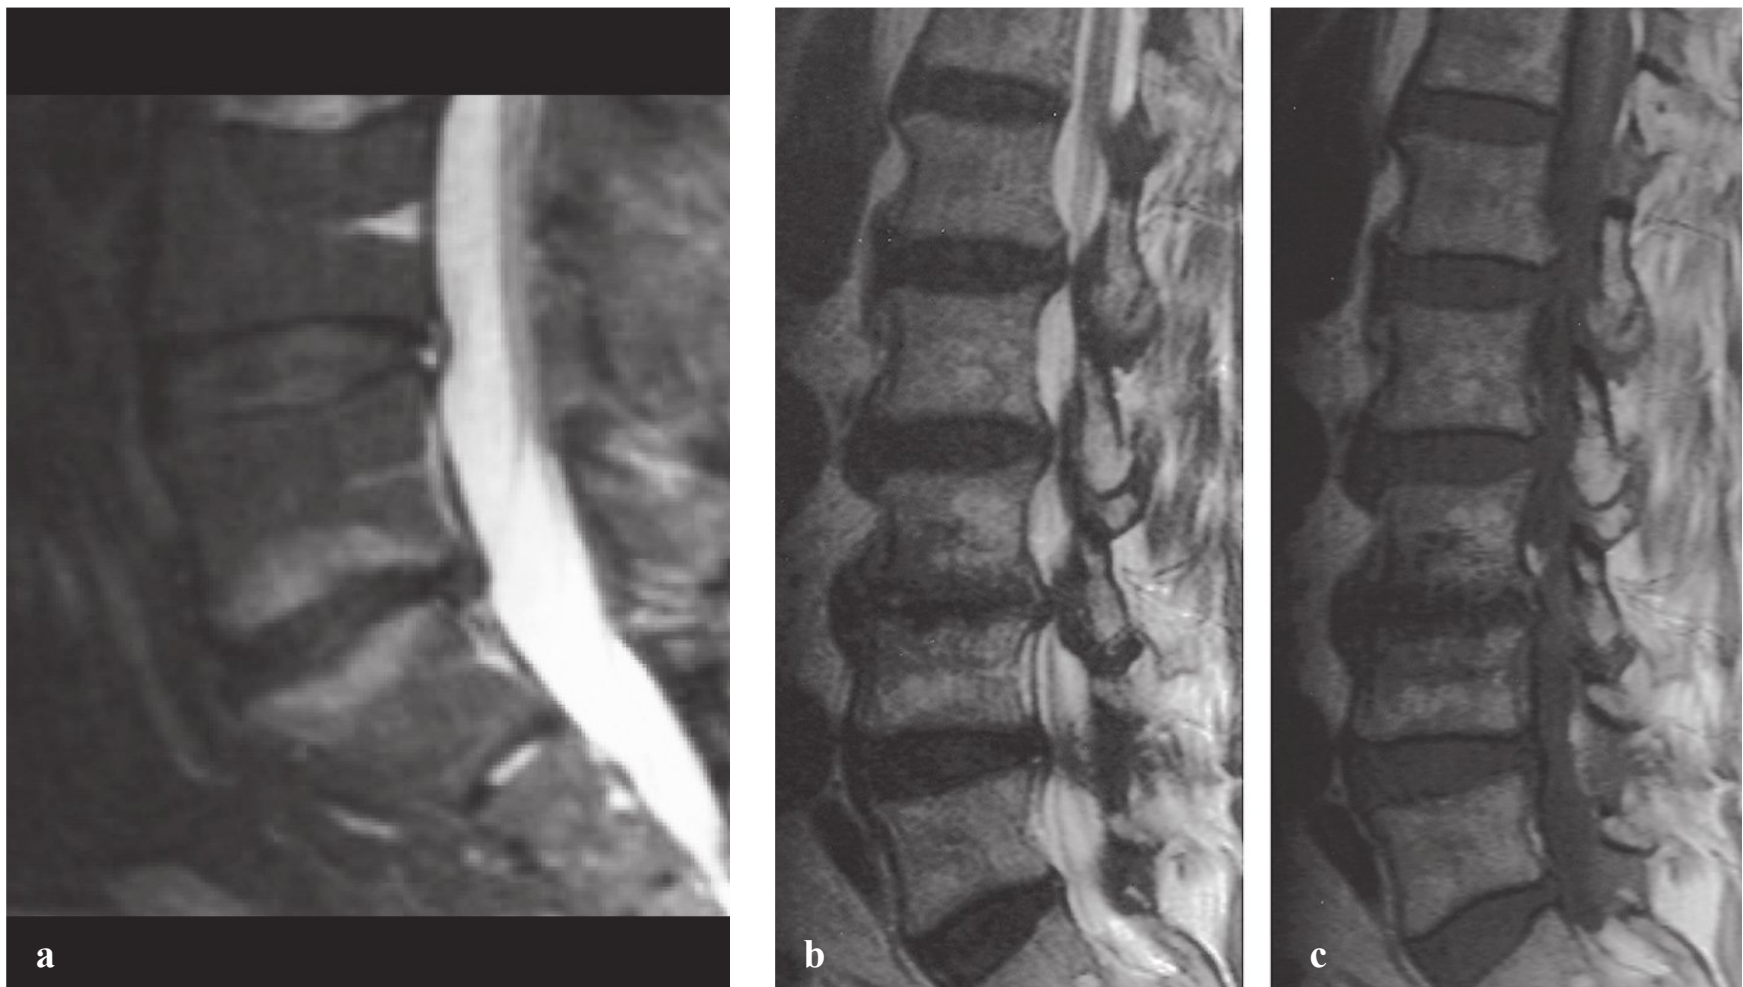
(a–c) Sagittal magnetic resonance imaging demonstrating type 1 Modic changes. (Reproduced from Imhof H, et al. Spinal Imaging. Direct Diagnosis in Radiology Series. Stuttgart, Germany: Georg Thieme Verlag; 2008: Figs. 3.4 and 3.5, with permission.)
